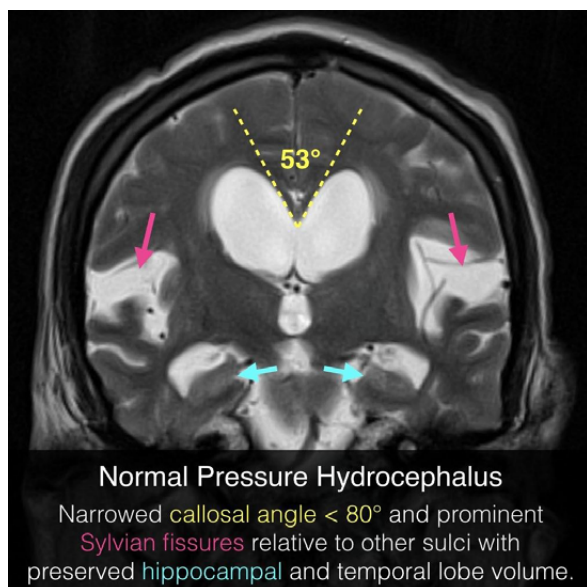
MRI image depicting hydrocephalus
